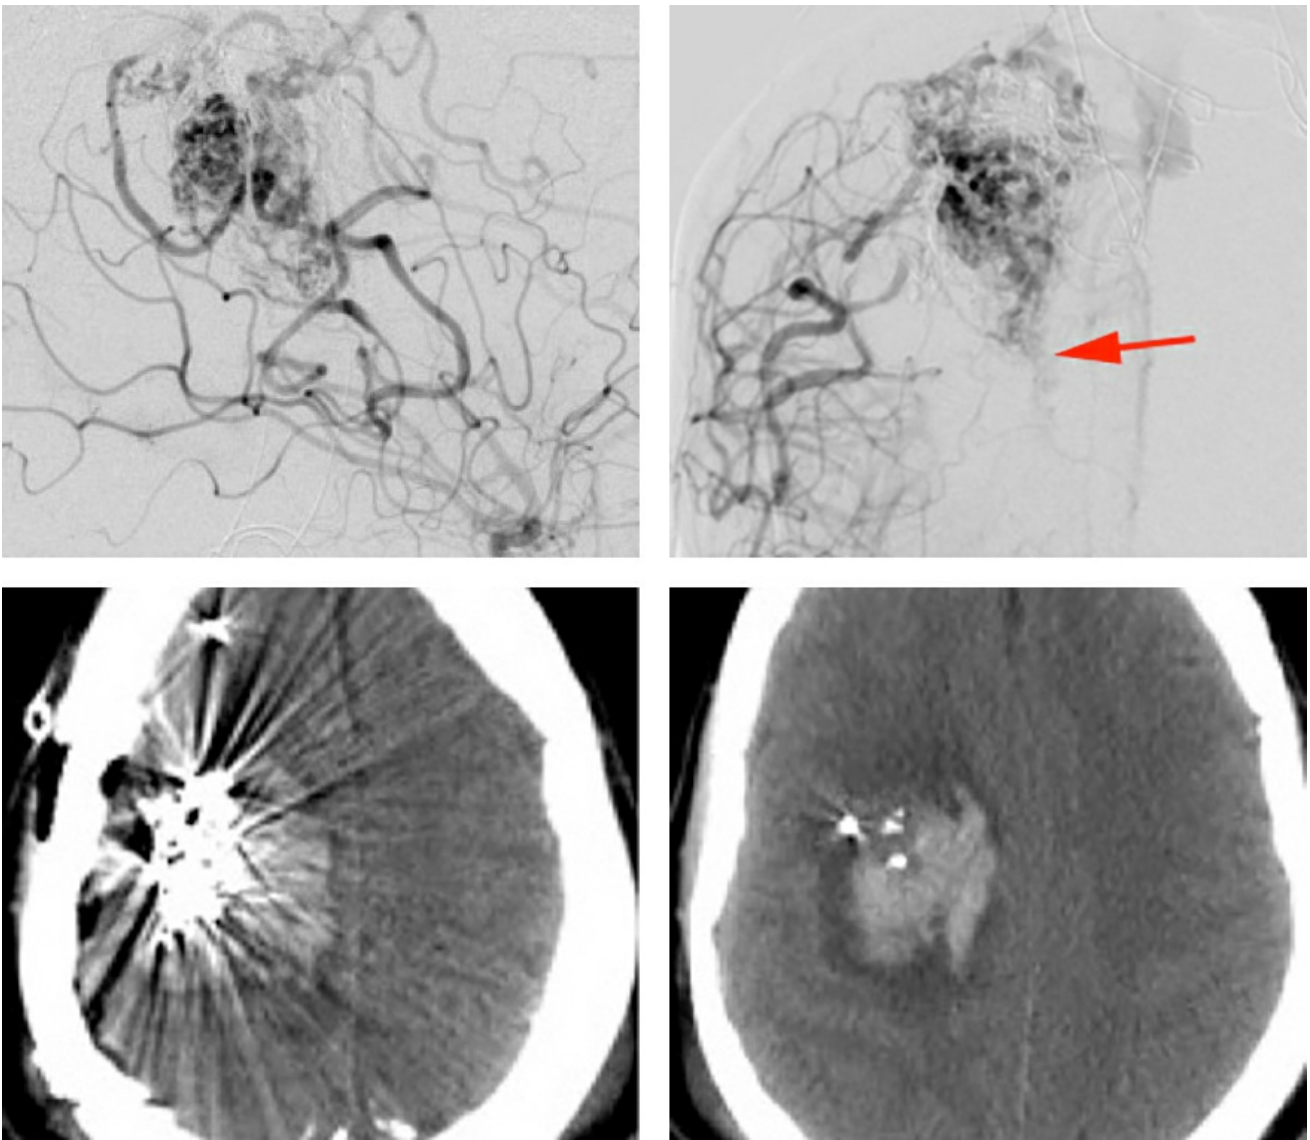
This posterior lateral frontal AVM was aggressively embolized which may have led to hypertrophy of its deep white matter feeders (upper row, anteroposterior and lateral ICA angiograms-red arrow). The resective operation was performed early in my career. Unfortunately, I did not manage the dominant deep feeders adequately. Intraoperatively, a large white matter feeder retracted into the brain and led to an intracerebral hemorrhage (lower row-postoperative CT) and resultant uncontrollable cerebral tension, mandating a premature abortion of the procedure and closure of the case. Partial devascularization of the AVM led to its significant shrinkage, making it very amenable to radiosurgery. The patient ultimately recovered well but suffered from a permanent minor hemiparesis.
